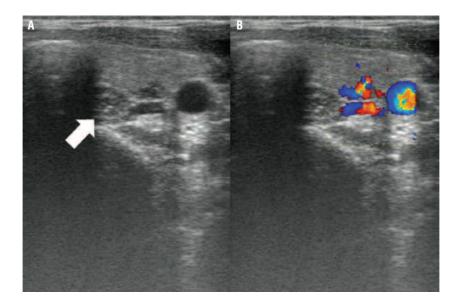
Differentiation of cystic lesions and vessels using the Doppler colour flow imaging. An arrow indicates the esophagus. The blood flow inside the lesions confirms the presence of normal vessels*
